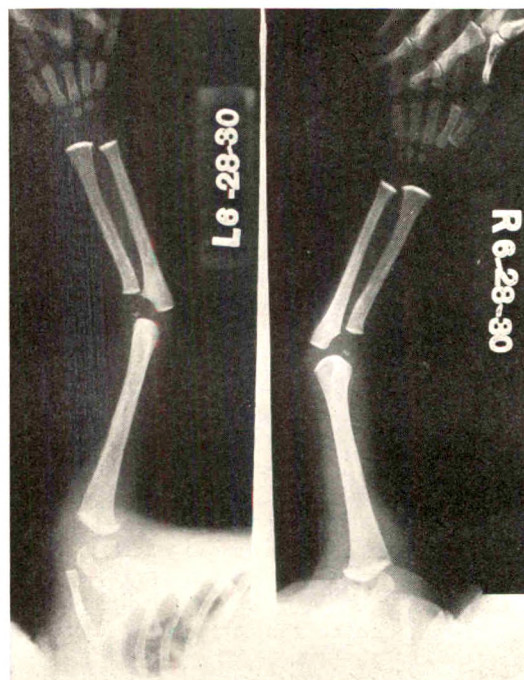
Roentgenograms of the case reported with lead-calcium determinations.
